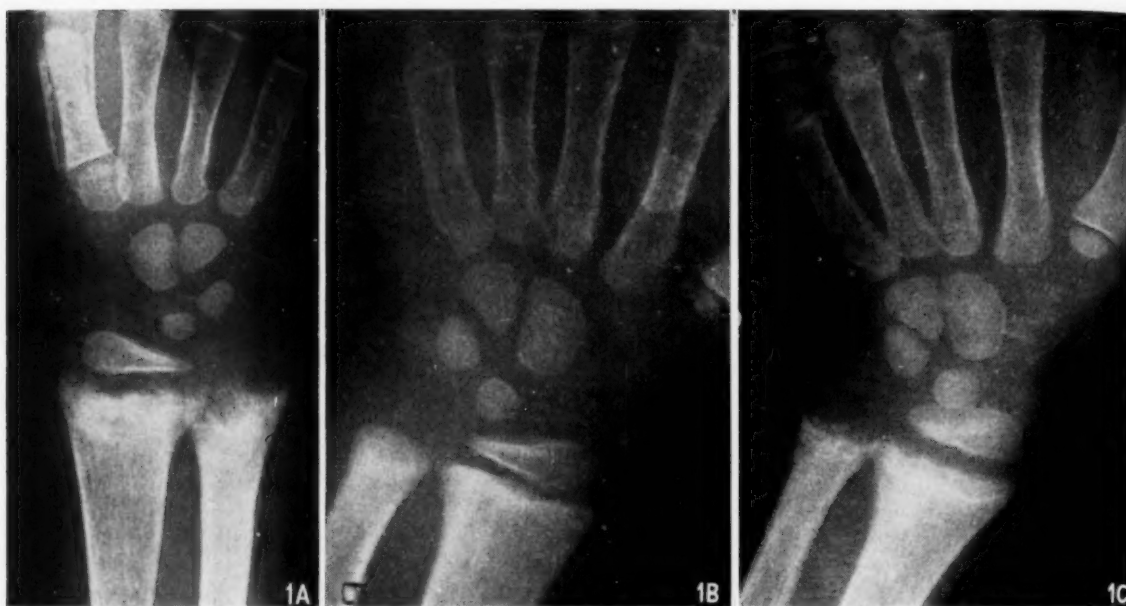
X-rays of wrists of patient D.A.: A. October 1958, showing active rickets; B. May 1959, showing healing after vitamin-D therapy; C. September 1960, showing recurrence of active rickets — no vitamin-D therapy since May 1959.
